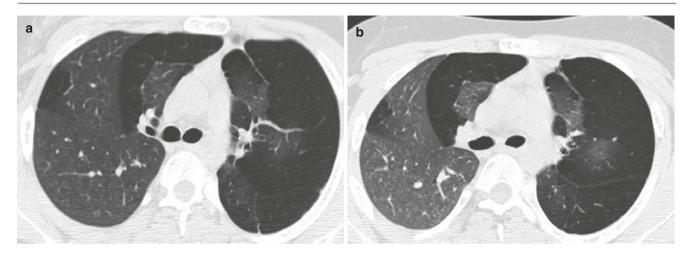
A 9-year-old boy with post-infectious bronchiolitis obliterans (Swyer-James syndrome). (a) Inspiratory CT image shows extensive mosaic attenuation. (b) Expiratory CT image shows air trapping
